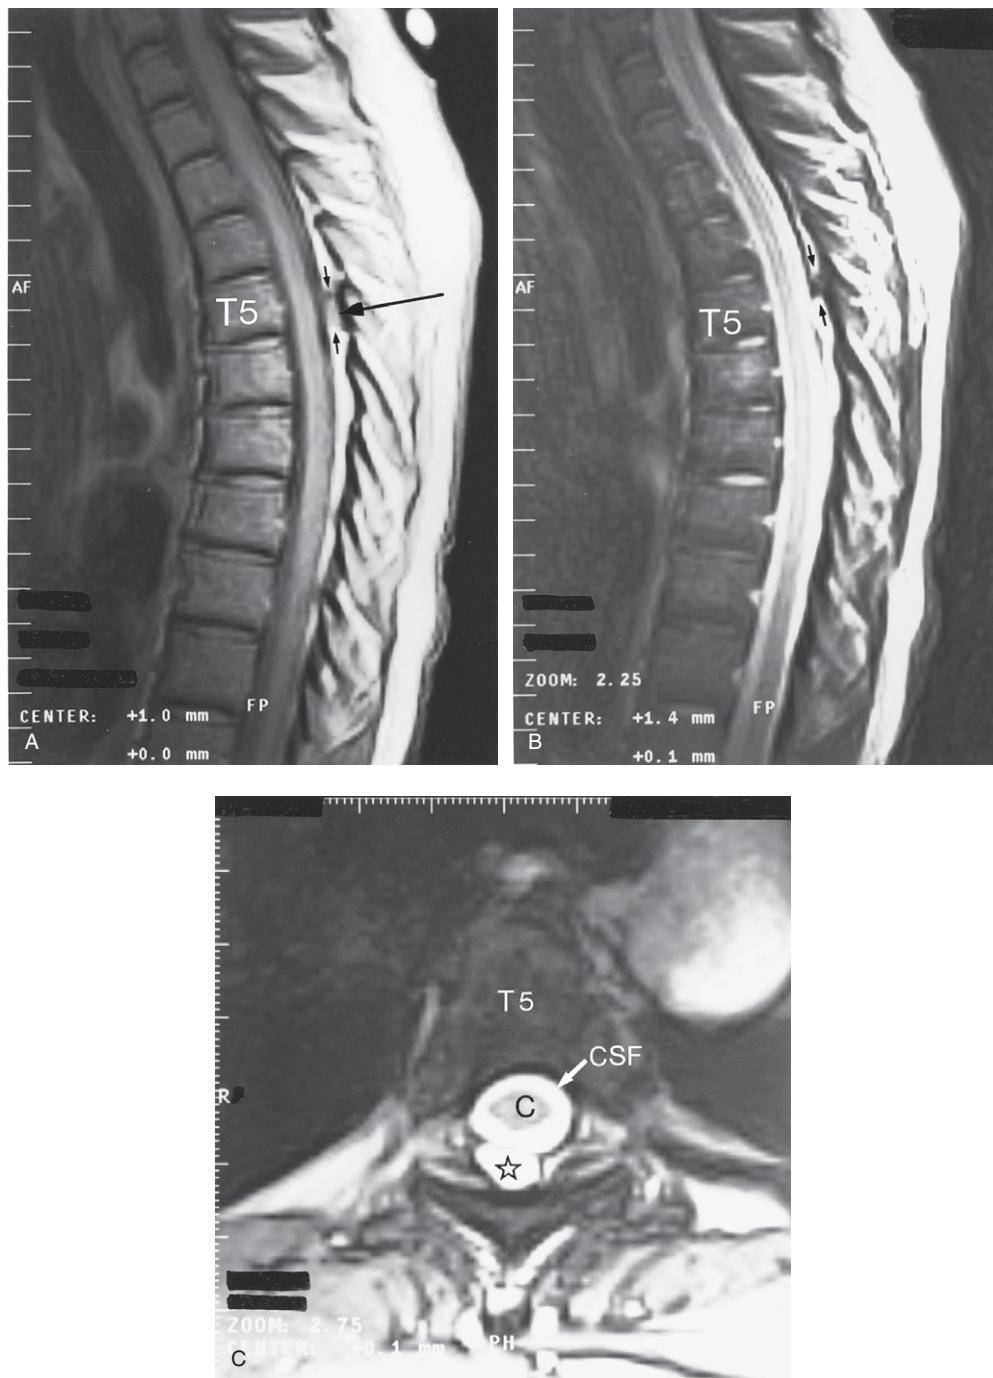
(A) Thoracic spine MRI sagittal T1-weighted image that shows the small cystic lesion (arrows) lying posterior to the thecal sac at the T5 level. There is no obvious mass effect on the thecal sac or spinal cord. (B) Thoracic spine MRI sagittal T2-weighted thoracic spine MRI scan that shows the small cystic lesion (arrows) lying posterior to the thecal sac at the T5 level. (C) Thoracic spine MRI axial T2-weighted image through the small cystic lesion showing the cross-sectional area of the lesion (star). C = spinal cord lying within the cerebrospinal fluid (CSF). T5 = fifth thoracic vertebral body.
